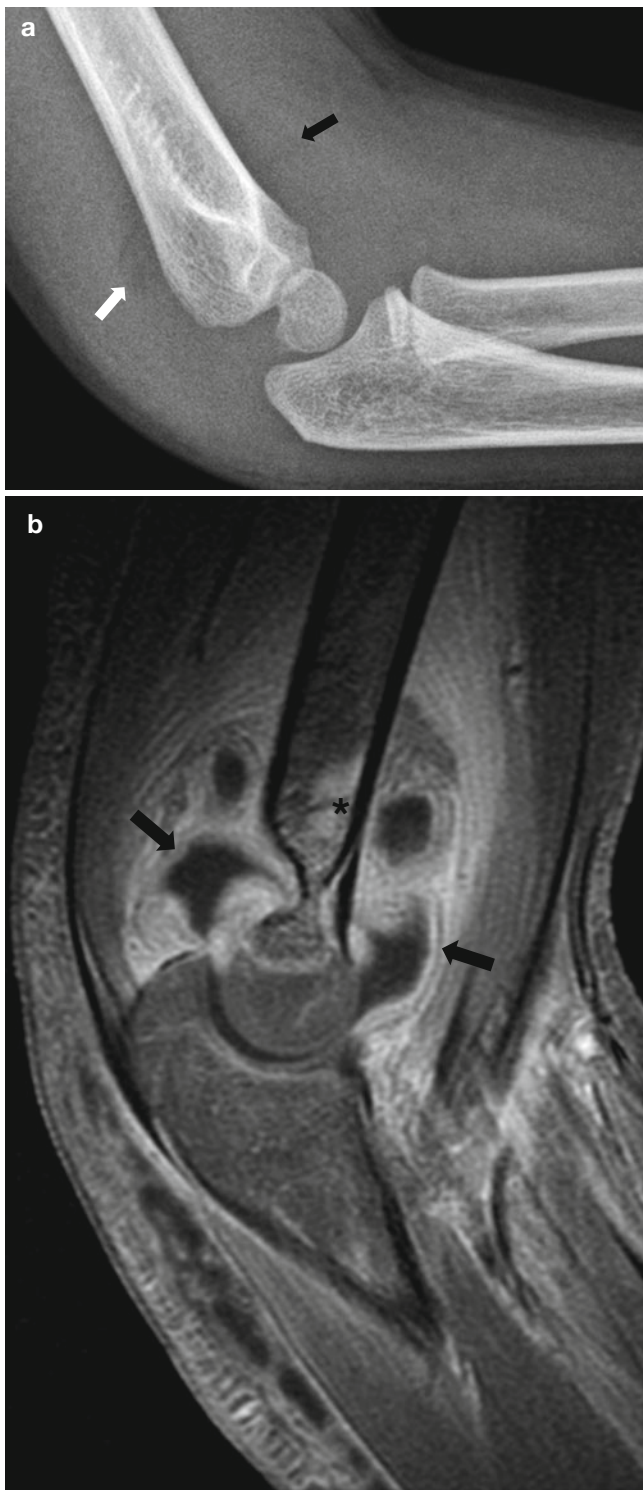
A 3-year-old girl with septic arthritis. (a) Plain radiograph of the elbow demonstrates a large joint effusion with shifting of the anterior (*black arrow*) and posterior (*white arrow*) fat pads. (b) Post-contrast sagittal T1-WI with fat suppression demonstrates abundant enhancing synovium (*black arrows*), soft tissue swelling, and bone marrow edema (*)
